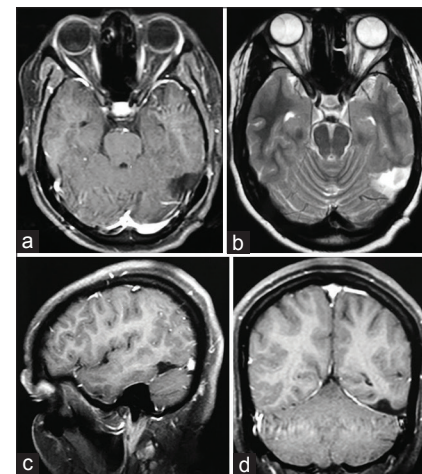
(a) Axial T1-weighted with gadolinium contrast. (b) Axial T2-weighted. (c) Sagittal T1-weighted with gadolinium contrast. (d) Coronal T1-weighted with gadolinium contrast. Postoperative images 5 years after surgery showing no recurrence of the lesion
